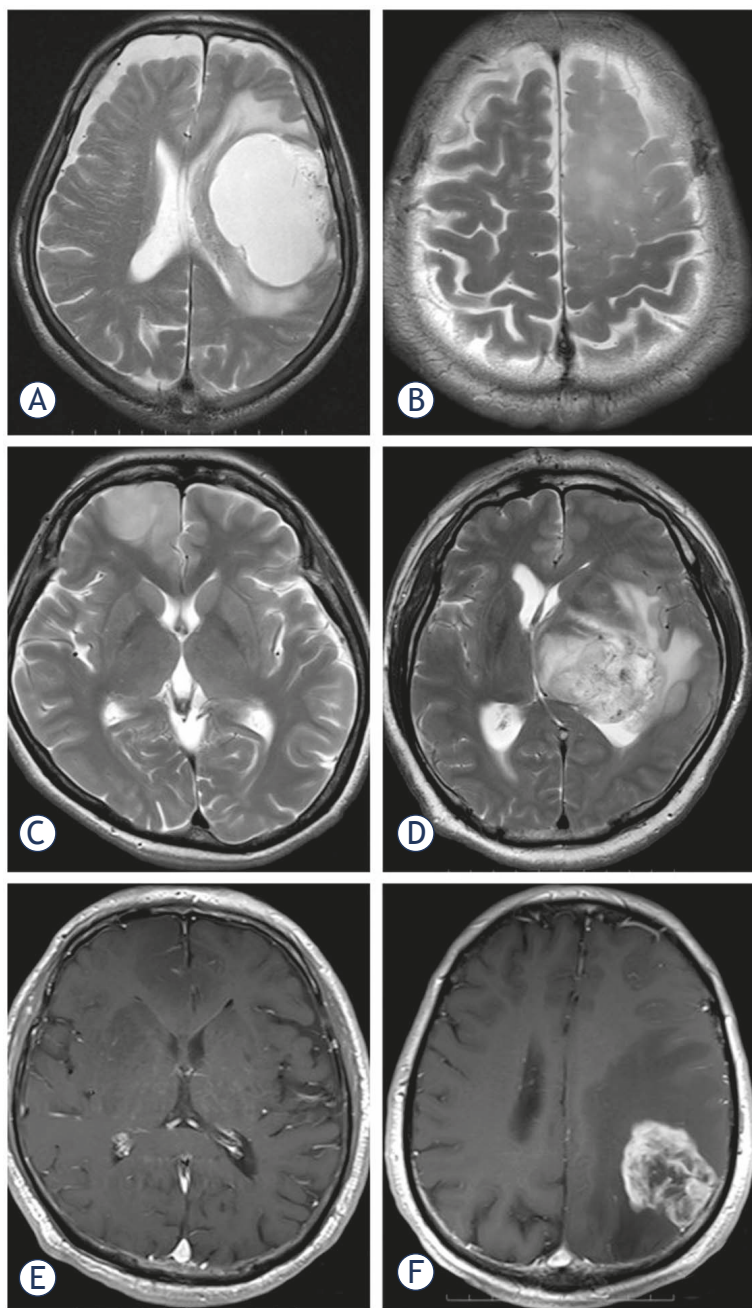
Comparison of tumor characteristics on MRI scans. Axial T2W images showing a mass with (A) a smooth and (B) an indistinct tumor border in the left frontal lobe, (C) homogeneous intensity in the right frontal lobe, and (D) heterogeneous intensity in the left thalamus. Axial gadolinium-enhanced T1W images show that (E) the tumor lacks contrast enhancement in the right frontal lobe and is (F) contrast-enhanced in the left parietal lobe.
